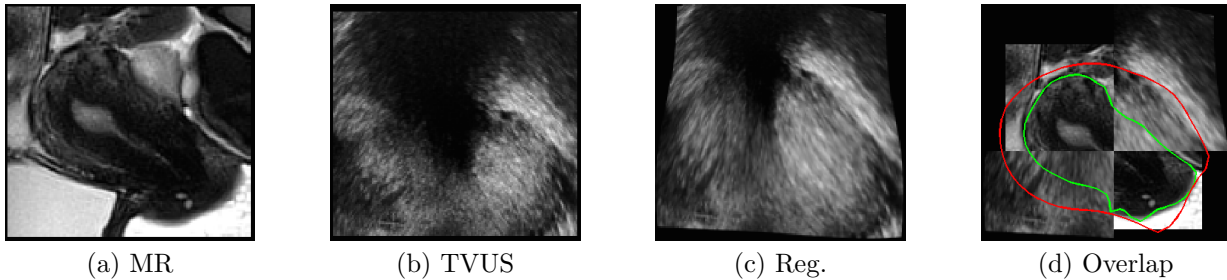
Registration result for an NMI-based registration method [11]. In the overlap image (d), the top right and the bottom left are the deformed TVUS data and also the top left and the bottom right are the MR data. In (d), the red curve shows the uterus’s shape after registration whereas the green curve shows the uterus’s shape in the MR image. The large disparity between the green and red curves shows that even on this very simple case, NMI-based registration cannot cope with type of data.
